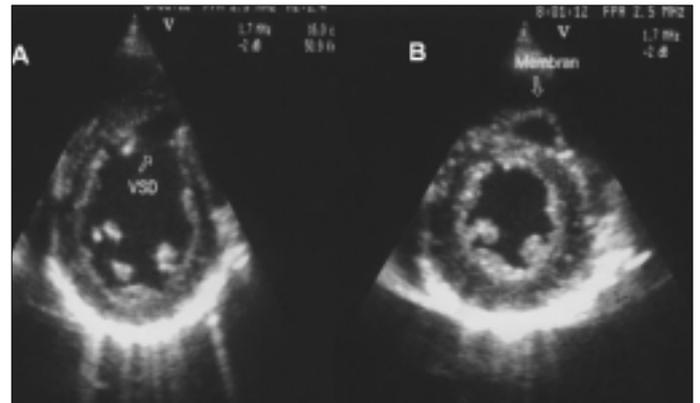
Parasternal short axis echocardiographic views (A and B) depicting the ventricular septal defect and the membrane
